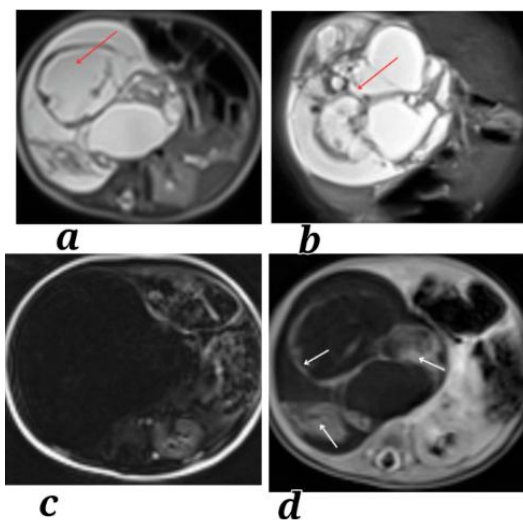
MRI images (a) axial T2W, (b) coronal T2W, (c) axial T1W without contrast, and (d) axial T1W with contrast - demonstrating a predominantly T2W hyperintense lesion with central hypointense septations and enhancing solid components.
